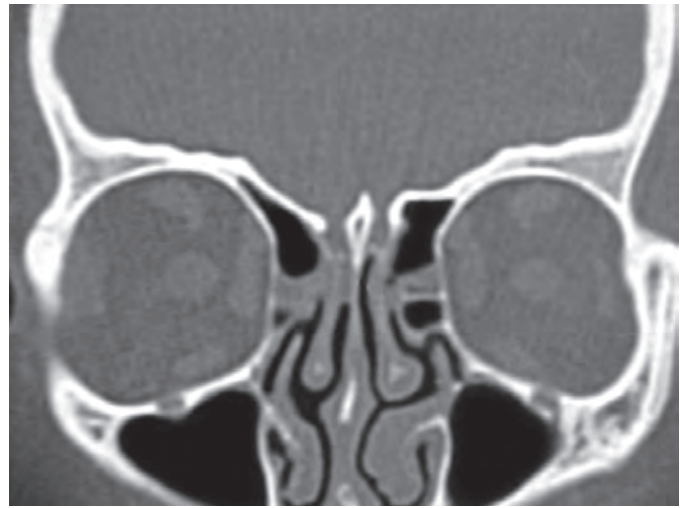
CT bone cuts coronal views showing bilateral cribriform plate defect in a patient who presented with delayed post-traumatic CSF leak
